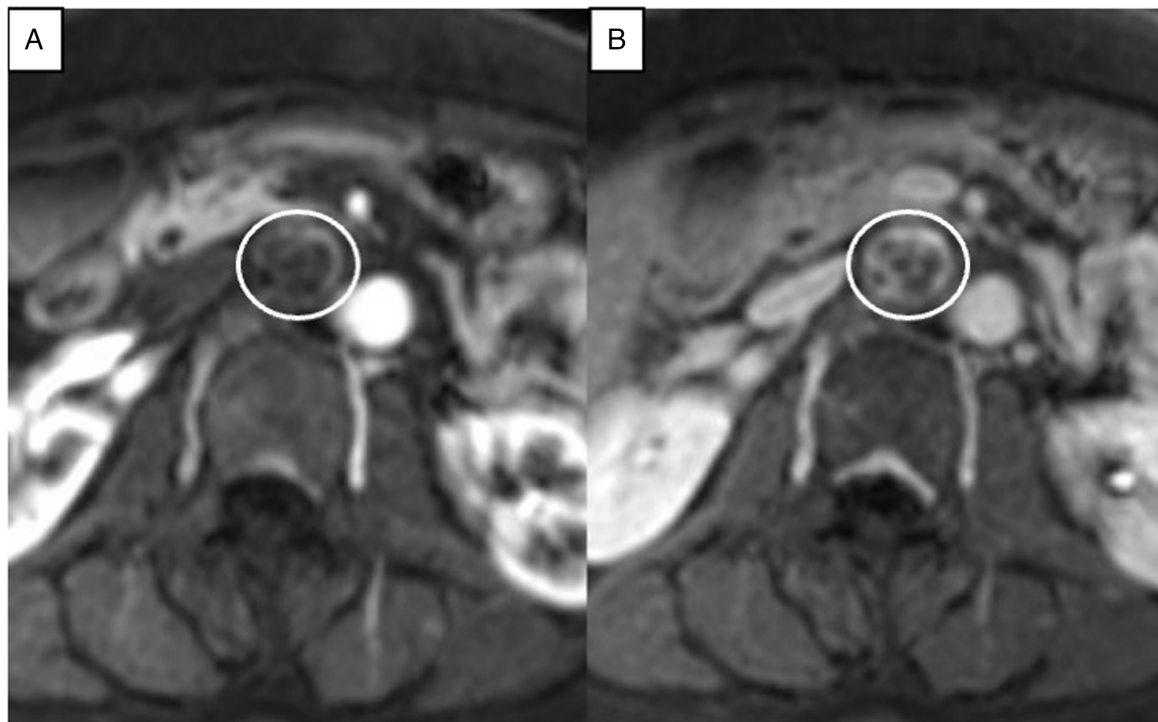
Postcontrast-enhanced abdominal MRI scan. The white circle indicates the retroperitoneal tumor. (A) Early phase of T1WI. (B) Delay phase of T1WI. The tumor presented with avid peripheral enhancement in the arterial phase, which persisted in the delayed phase without central enhancement. T1WI, T1-weighted imaging.
